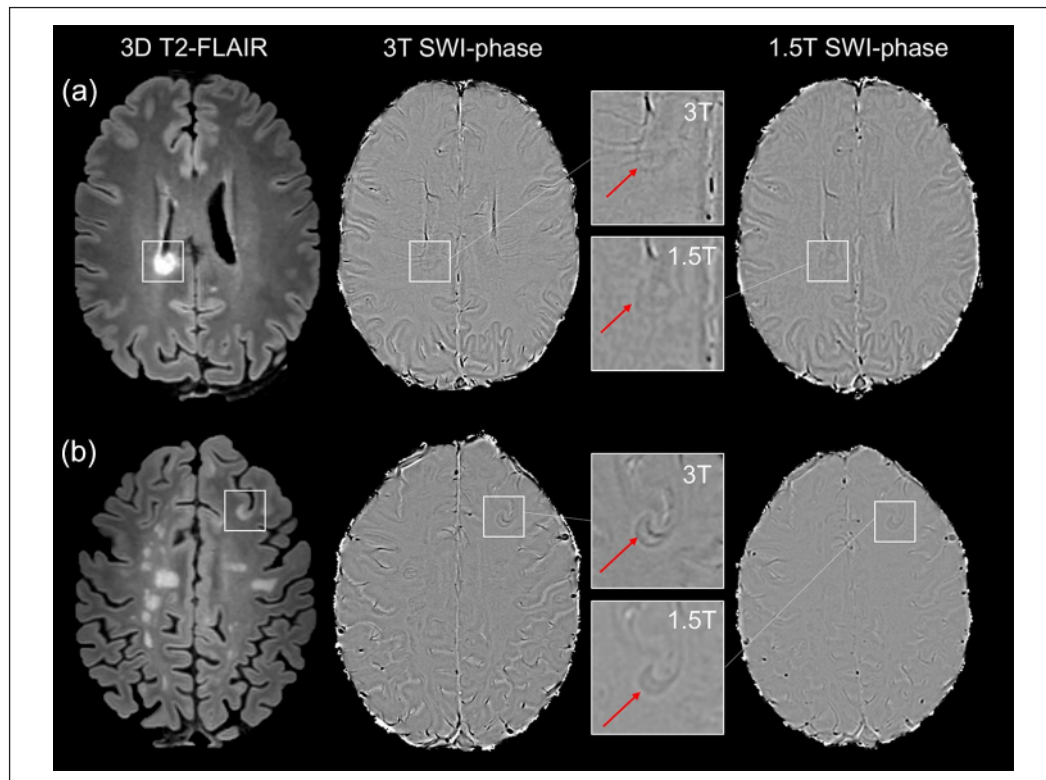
Concordant PRL at 1.5T and 3T MRI. (a) Axial 3D FLAIR and SWI phase images from subject #7 (Table 1) showing a comparable visualization of a periventricular PRL at different magnetic fields. The time lapse between scans was 0.3 years. (b) Axial 3D FLAIR and SWI phase images from subject #11 (Table 1) showing a leukocortical PRL at both 1.5T and 3T. The time lapse between scans was 2.5 years. For both cases, PRL magnification is shown in the insets at both 1.5 and 3T MRI. In both cases, a clear distinction between the hypointense phase rim and the isointense core of the lesion can be noticed.
